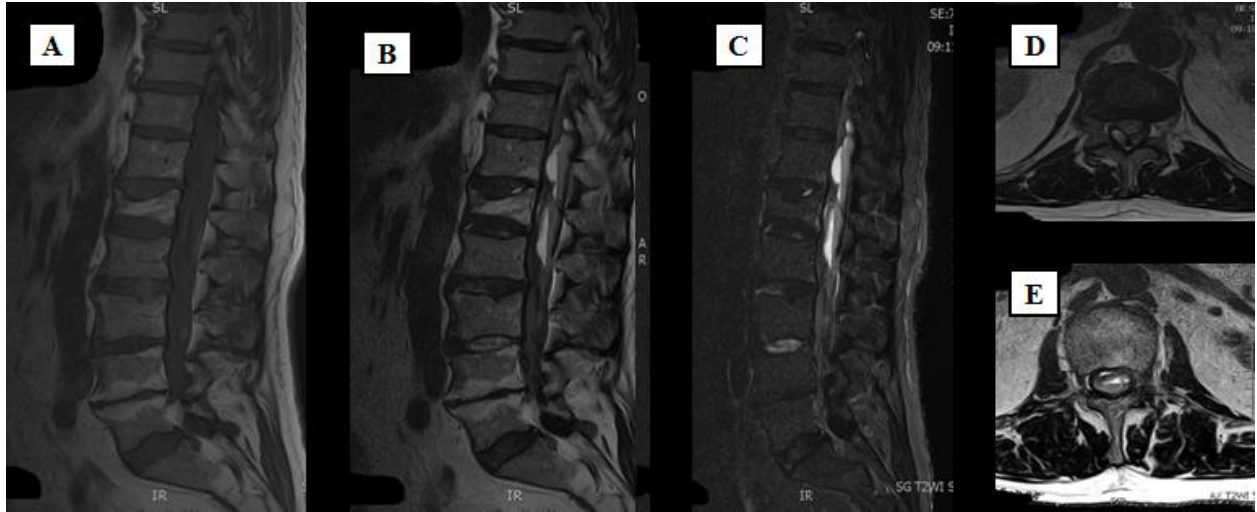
Spine MRI performed 4 days after the onset of symptoms. (A) Sagittal T1W image showing Th12-L2 isointense subdural hematoma; (B) Sagittal T2W image showing Th12-L2 hyperintense subdural hematoma; (C) Sagittal STIR sequence showing hyperintense signal of SSDH; (D) Axial T2W showing the “Y” shaped sign of the SSDH at the level of L1; (E) Axial T2W showing SSDH at the level Th12 causing absolute spinal stenosis.
